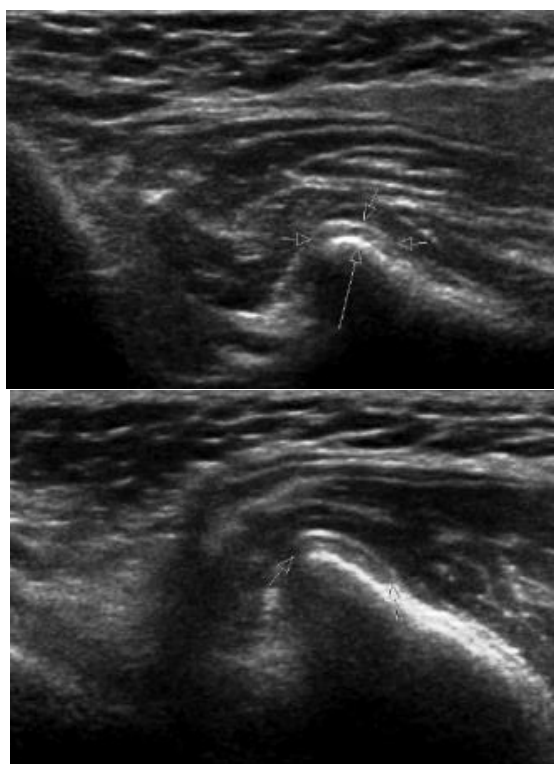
TMF ultrasound in JIA (a, b)
